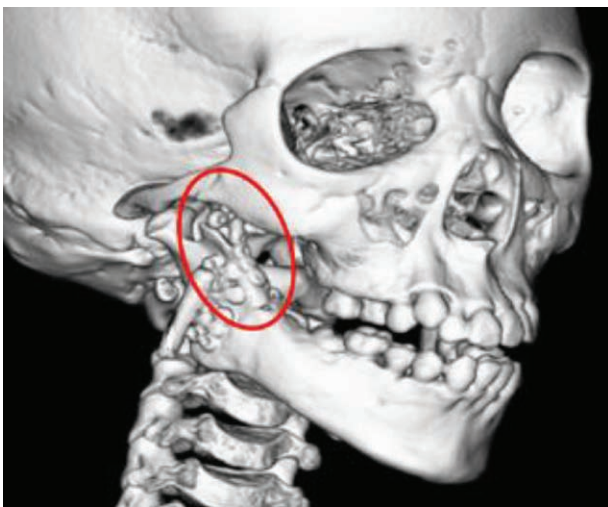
Check plate prevents rotational forces about the TMJ. 3D CT reconstruction depicting use of the check plate (red oval) to engage the zygomatic arch to prevent undesirable rotational forces.
